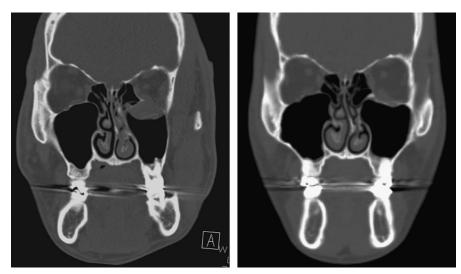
Coronal views of preoperative and postoperative CT.
